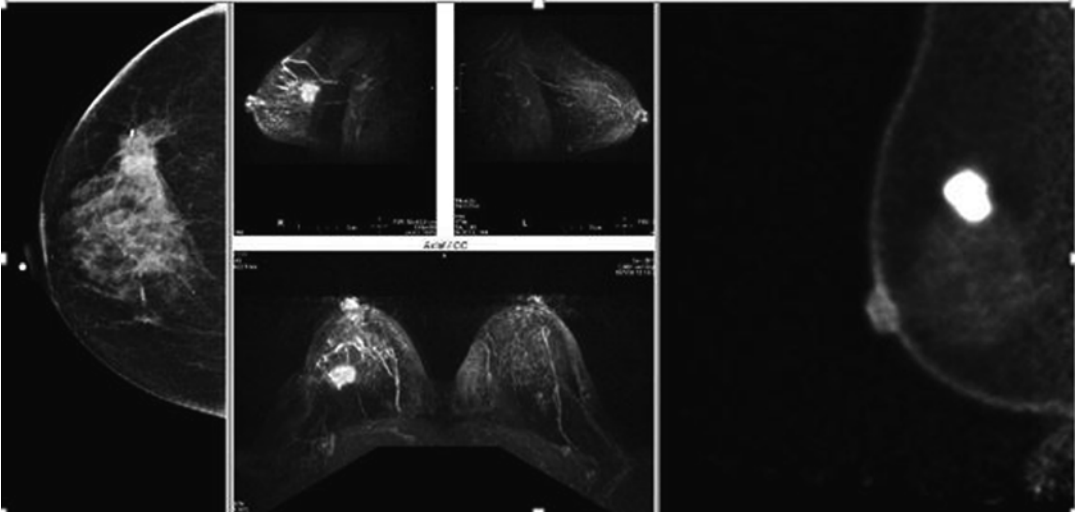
Comparison view, mammogram, MRI breast, and PEM of the same patient
